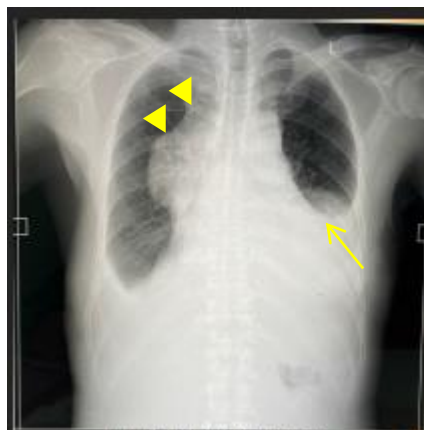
Initial chest radiography of the patient showed pleural effusion (arrow) and enlargement mediastinal (arrow head).
